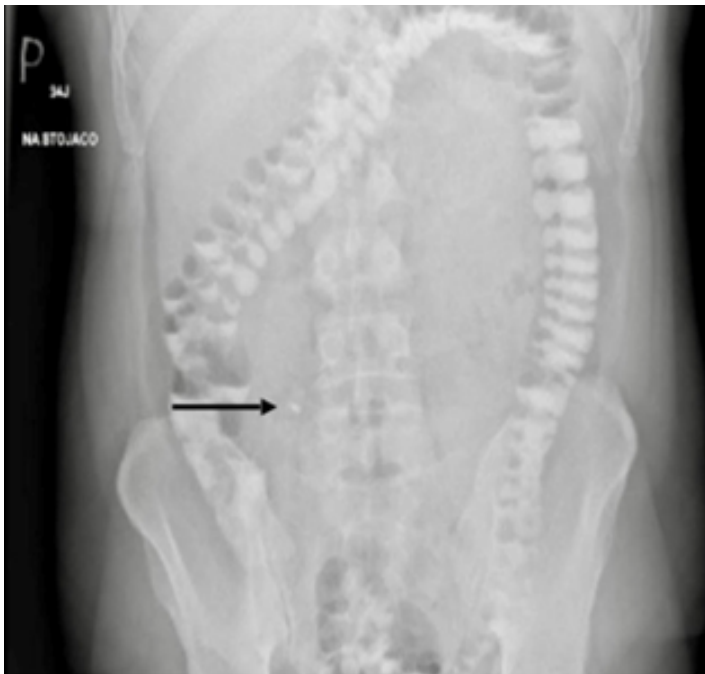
X-ray of the abdomen black arrow indicates the IGB catheter.
